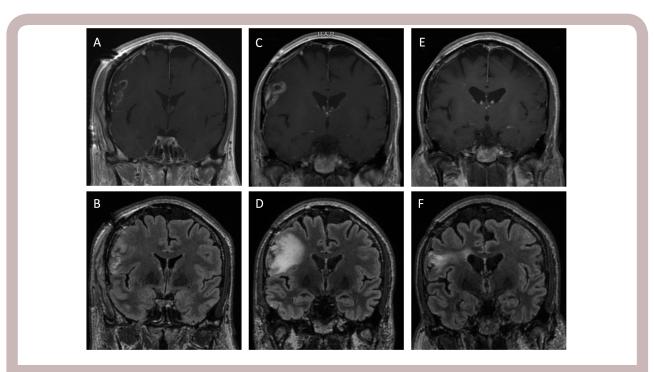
Pseudoprogression observed in a patient with right frontal, MGMT-methylated glioblastoma. Postoperative coronal MRI demonstrating subtotal resection of right frontal glioblastoma by (A) T1 postcontrast and (B) fluid attenuation inversion recovery (FLAIR). MRI 3 months after completion of radiation, demonstrating (C) thickened nodular enhancement on T1 postcontrast imaging and (D) increased edema on FLAIR. The patient was asymptomatic and completed 1 year of adjuvant temozolomide. MRI at 22 months after completion of radiation and 10 months after completing 1 year of adjuvant temozolomide, (E) resolution of enhancement and (F) resolution of edema with residual gliotic changes.
